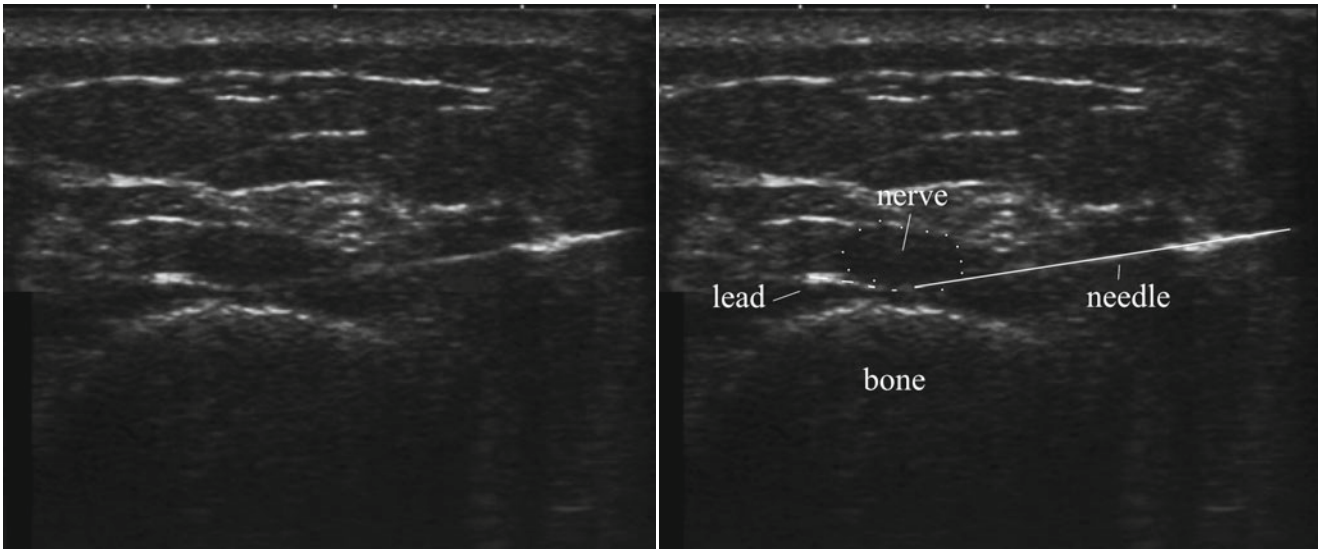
Ultrasound-directed peripheral nerve stimulator placement (Image from Elahi et al. [58], with permission)
